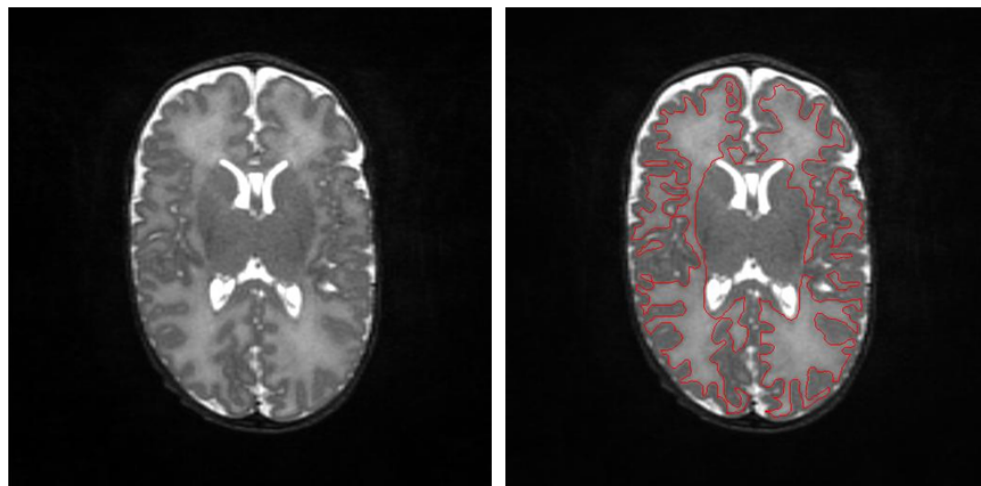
Left: An original T2 brain MR image of a premature infant. Right: The same image where the contours of the white matter region are marked in red. The objective of this study is to automatically detect and measure the white matter volume.
